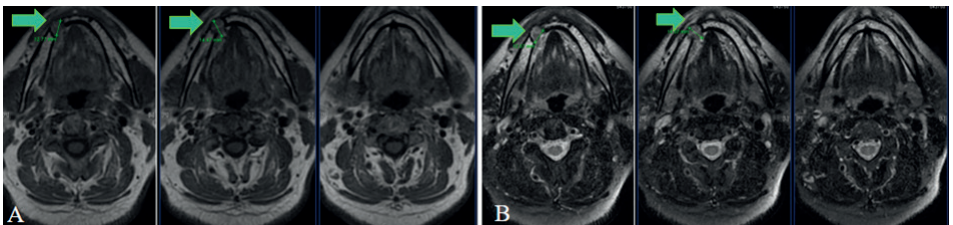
MRI image taken at an external centre, two years before the first examination
